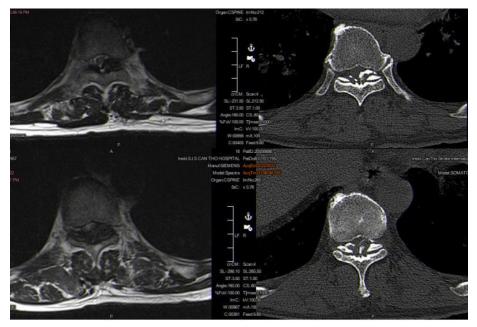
MRI (A) and CT-Scan (B) Axial images at T8-9 (above) and T10-11 segments (below).
